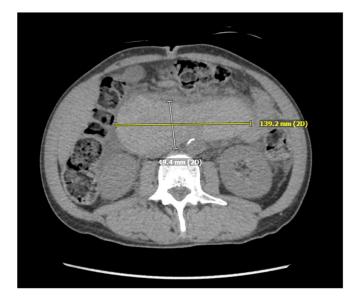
CT scan without contrast showing the size of the duodenal hematoma:  $139.2 \times 49.4$  mm.
